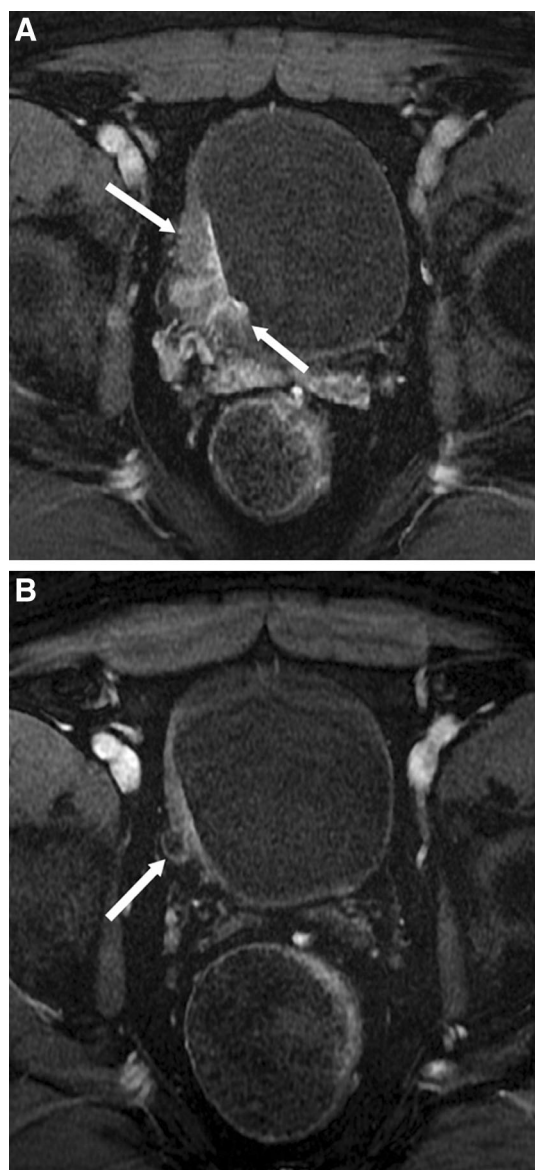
45-year-old man with high-grade muscle-invasive urothelial carcinoma of the bladder with response to neoadjuvant chemotherapy (cT3b stage). A Axial fat-suppressed gadolinium chelate-enhanced T1-weighted MRI at diagnosis shows infiltrative irregularly enhancing right bladder wall thickening (*white arrows A*). B Follow-up axial fat-suppressed gadolinium chelate-enhanced T1-weighted MRI after 6 months of neoadjuvant therapy shows significant interval decrease of the right bladder wall mass and a small bladder diverticulum, representing response to neoadjuvant treatment.
